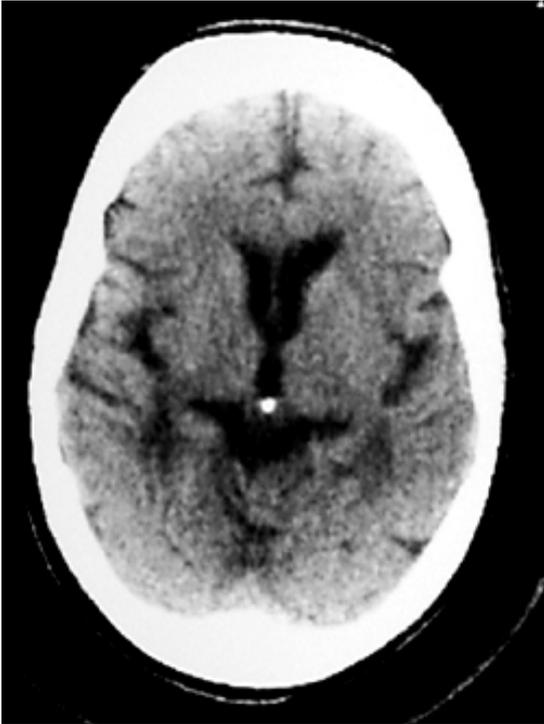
This computed tomography scan shows the pineal gland with calcareous concretion (brain sand) and the third ventricle.
